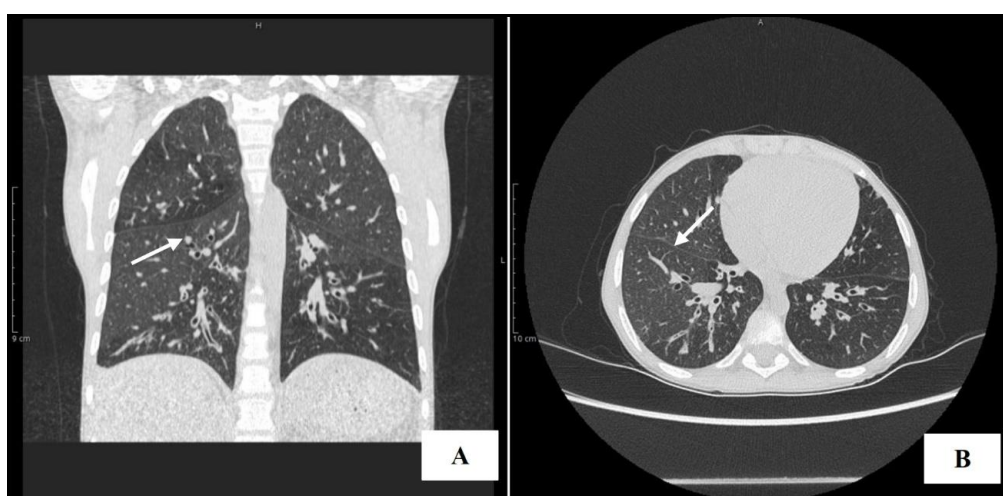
Chest computerized tomography (CT) of a patient at age of 3 years with LPS- responsive beige-like anchor protein (LRBA) deficiency showing multiple lymph nodes in both lungs (A) and Bronchiolitis Obliterans (B). Specifically, both images exhibit bilateral lower lobe and right upper lobe peribronchial thickening and mild bronchiectasis change with tree-in-bud appearance.
